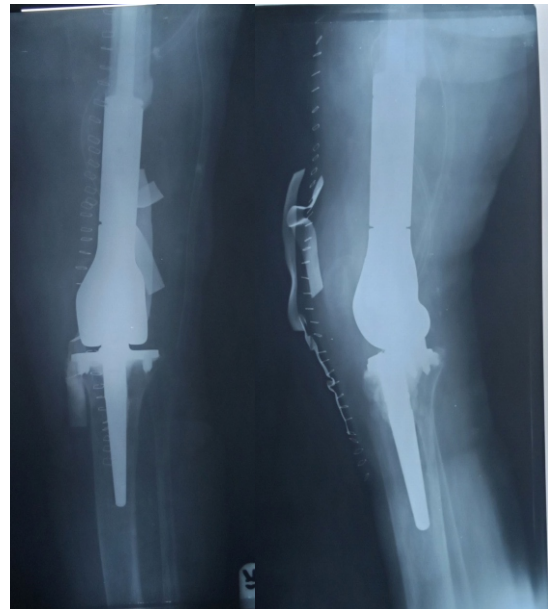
Anterior- posterior and lateral x-ray views of the right knee following the distal femoral replacement
